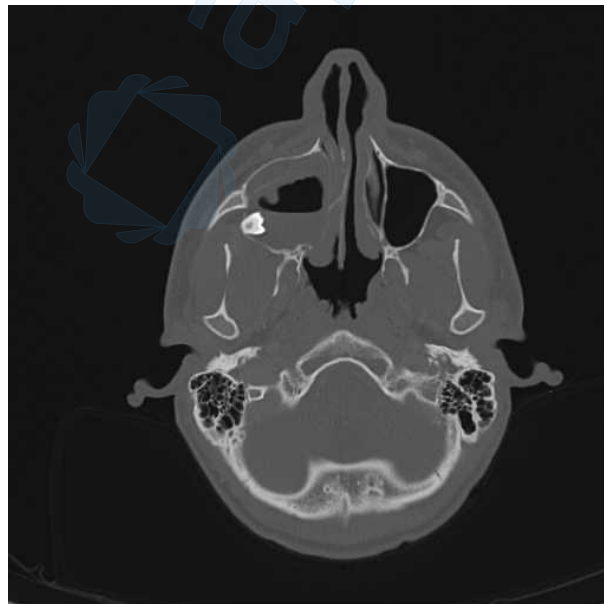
Inflammation of the maxillary sinus associated with a displaced tooth (CT).
